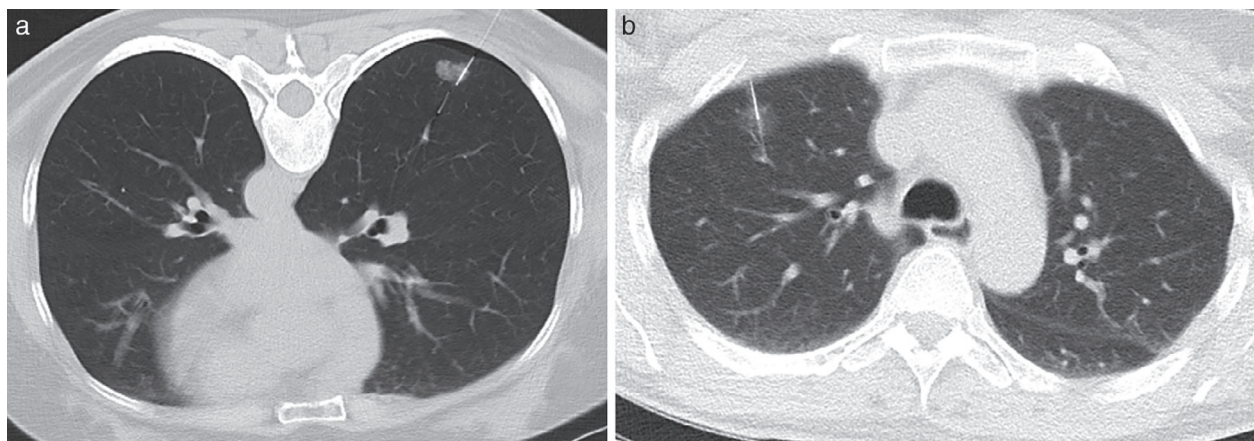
Computed tomography-guided hook-wire localization by two protocols. (a) Standard dose protocol: axial image shows successful hook-wire placement into a pulmonary nodule in the right lower lobe of a 48-year woman. Asymptomatic minor pneumothorax was observed. (b) Ultralow dose protocol: axial image shows successful hook-wire placement into a pulmonary nodule in the right upper lobe of a 58-year woman.
